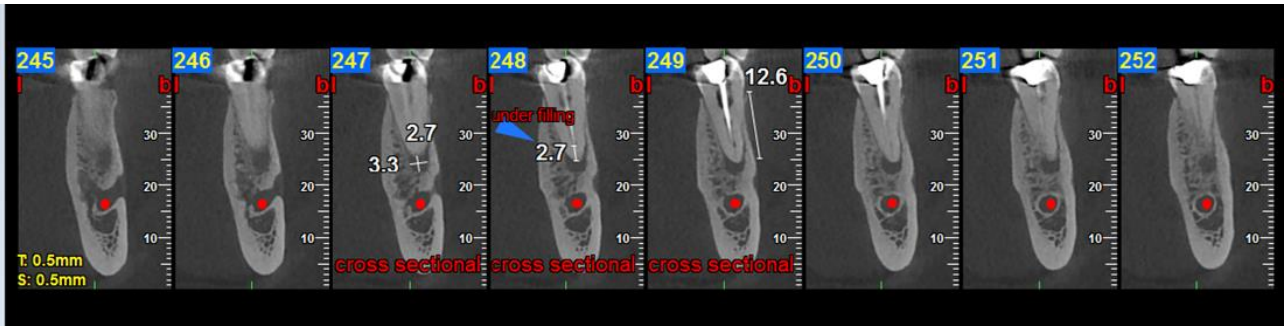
Cross-sectional CBCT image of tooth #20 with root canal treatment
